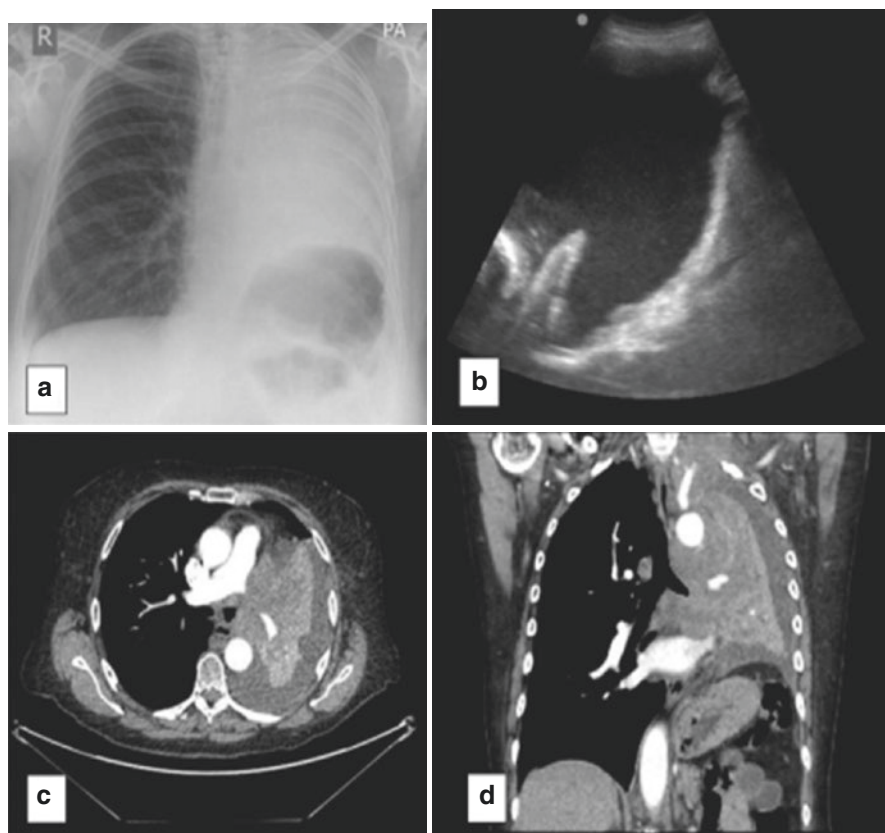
(a) Chest radiograph showing complete whiteout of the left hemithorax. The central location of the trachea concurs with the presence of underlying lung collapse and pleural effusion. (b) Thoracic ultrasound showing an echogenic pleural effusion, diaphragmatic inversion and nodularity. Transverse (c) and coronal (d) computed tomography images confirming complete left lung collapse and an associated pleural effusion. (Produced with permission from Wilczynska and Davies [34])
